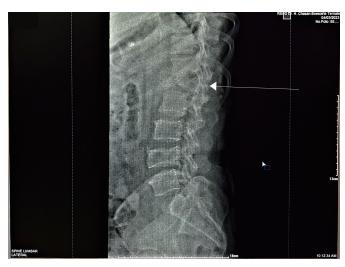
The second lateral thoracolumbar radiography (March 4th, 2023) after bone setting manipulation, showed 1st lumbar vertebra burst fracture (arrow) and reduced sagittal vertebral height.
